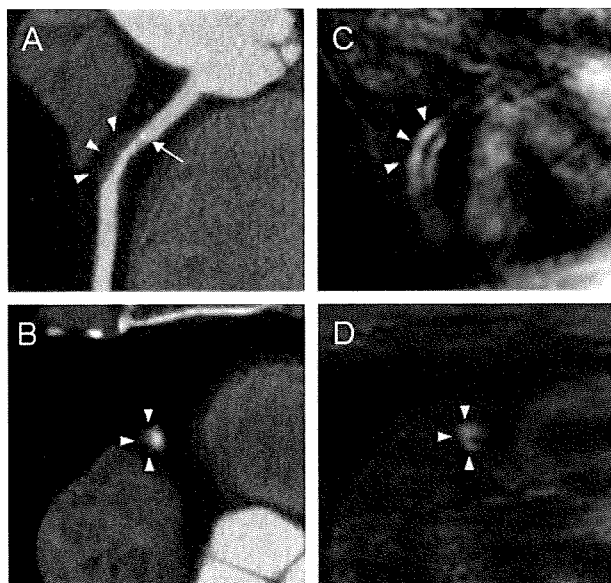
Multislice computed tomography (A, curved multiplanar reconstruction; B, horizontal) demonstrates low-density plaque (–36 Hounsfield units, remodeling index 1.6, arrowheads) with spotty calcification (arrow) in the proximal segment of the right coronary artery. On the corresponding noncontrast T1-weighted magnetic resonance imaging (C, oblique image; D, horizontal), this low-density plaque was visualized as a hyperintense lesion (arrowheads).
